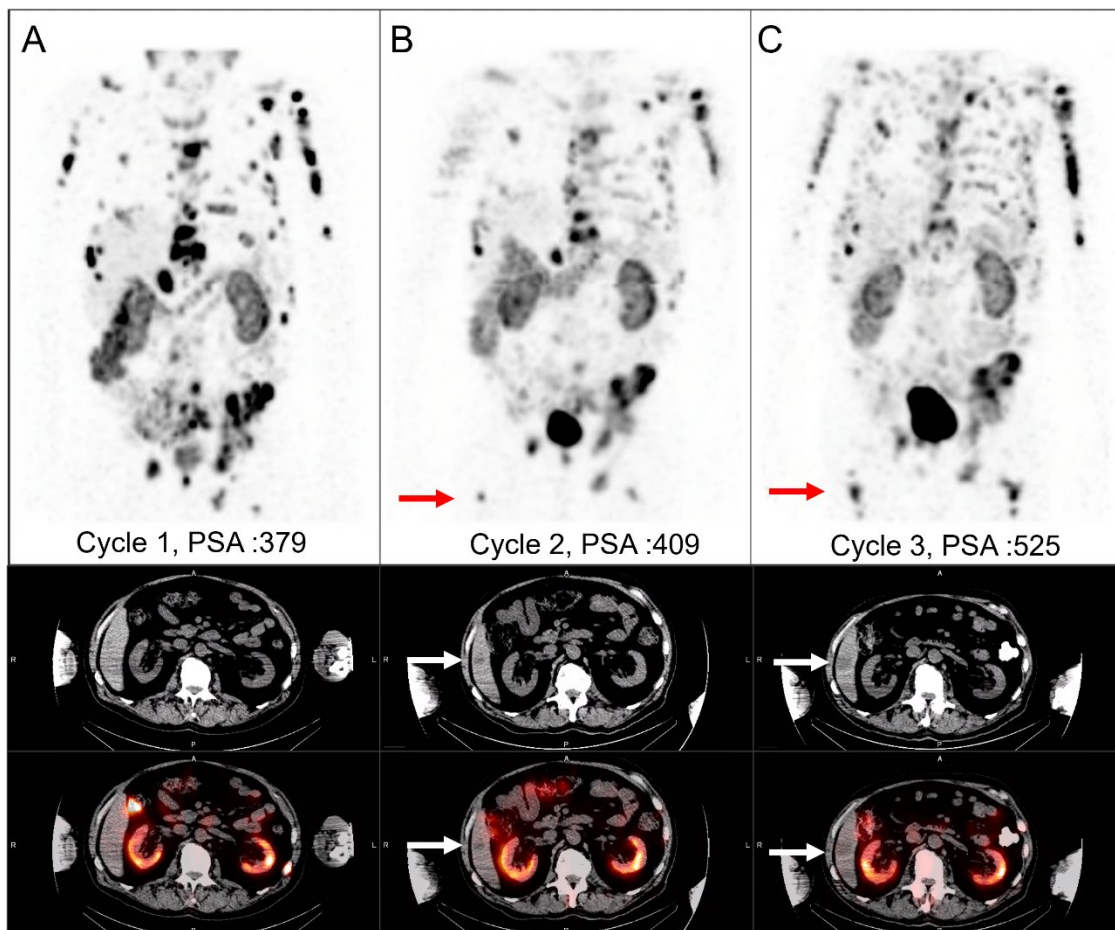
Serial  $^{177}\text{Lu}$ -PSMA SPECT/CT images across treatment cycles take 24 hours post-injection. A) Maximum intensity projection (MIP) SPECT, CT and fused SPECT/CT images at cycle 1. B) At cycle 2, MIP SPECT shows a new PSMA-avid bone lesion in the right femur (red arrow), along with decreased uptake in some pre-existing lesions. CT and SPECT/CT reveal a new non-PSMA-avid hepatic lesion (white arrow). C) By cycle 3, MIP SPECT demonstrates multiple new PSMA-avid osseous metastases and increased uptake in existing lesions. CT and SPECT/CT show further enlargement of the non-PSMA-avid hepatic lesion and the appearance of additional new hepatic lesions (not shown). PSA levels (ng/ml) for each cycle are shown below the images
